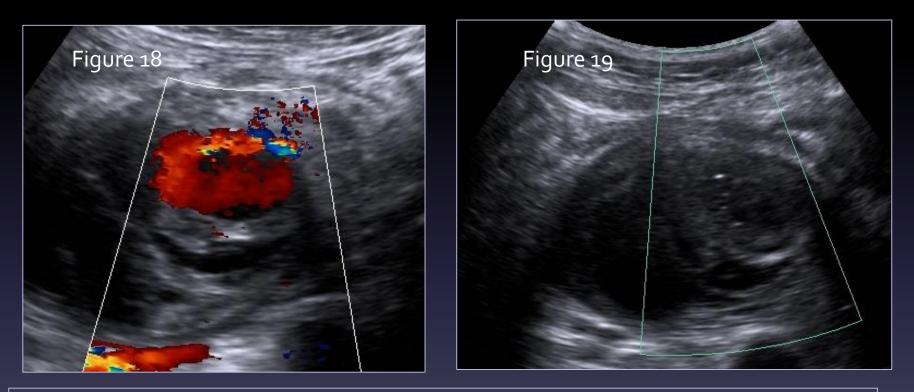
Doppler flow within a psuedo-aneurysm Figure 19 – No residual Doppler flow post ultrasound guided thrombin injection of the pseudo-aneurysm
